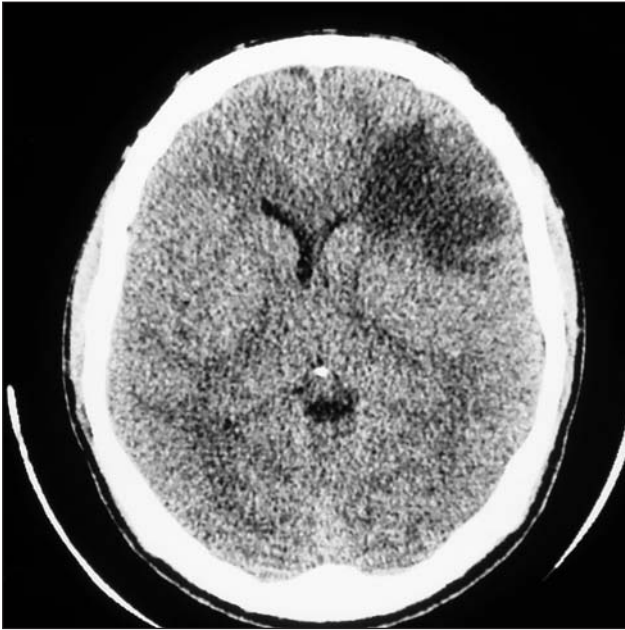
CT of sample case with hypodense lesion.
